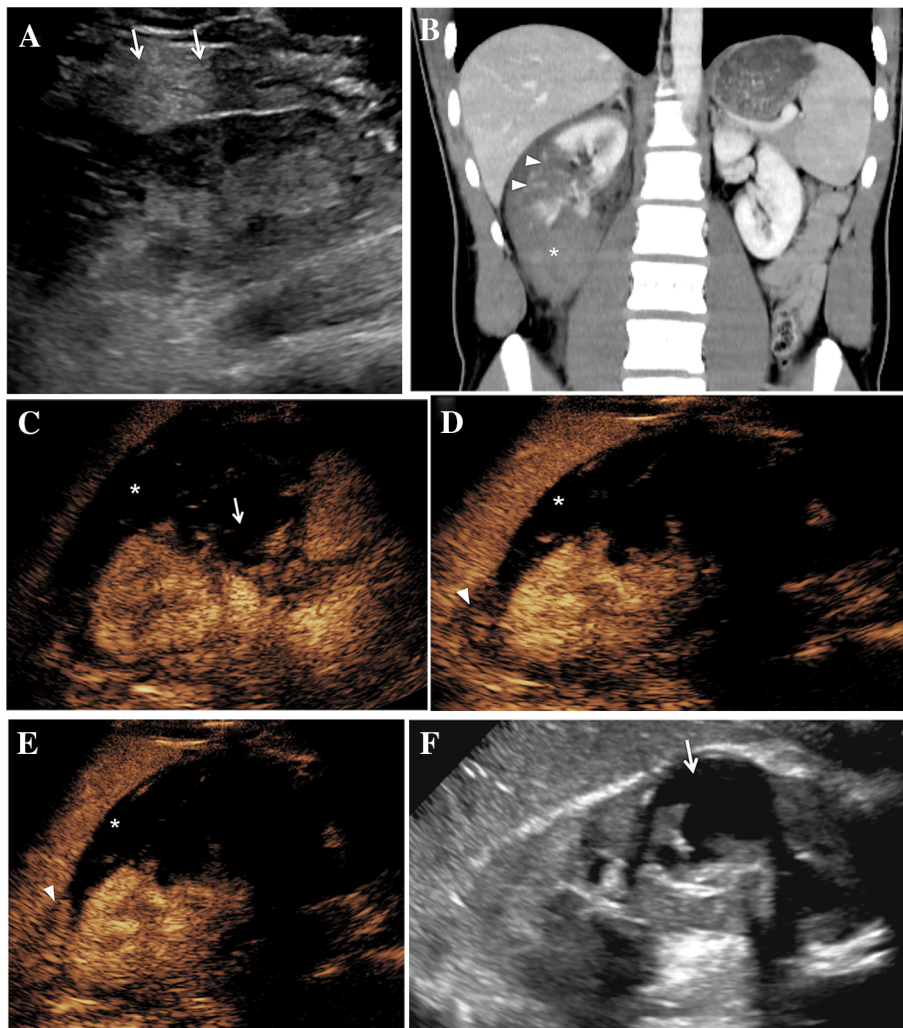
IV CEUS. Active Bleeding. 16-year-old boy kned in the abdomen during a baseball game. A Initial gray-scale ultrasound images show an acute perinephric hematoma - around the right kidney (arrows). B Contrast-enhanced Computed Tomography (CT), coronal reformat. A shattered right kidney (arrowheads) with a large perinephric hematoma (asterisk). C There was concern for active bleeding due to a sudden drop in hemoglobin from 11 to 8 mmol/L. Contrast-enhanced ultrasound was performed. Following intravenous injection of the ultrasound contrast agent, there is large
